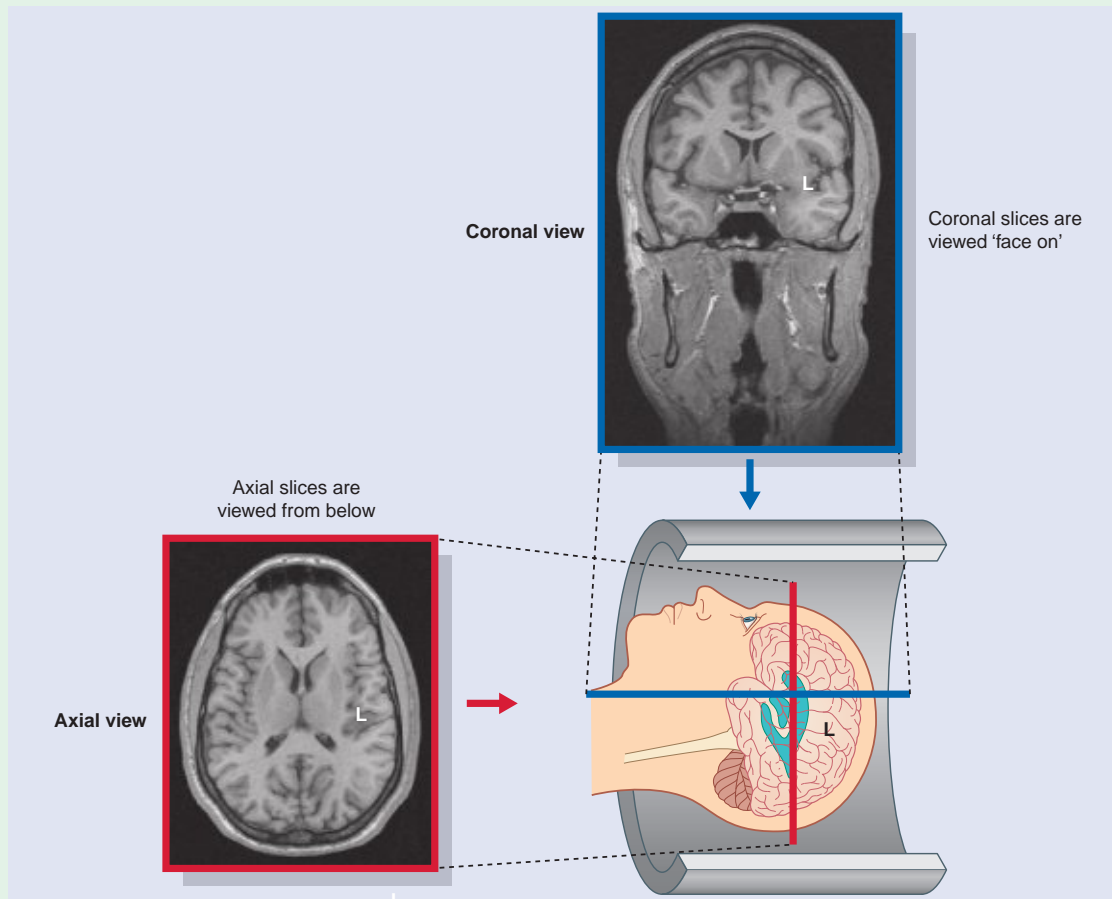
Standard orientation of magnetic resonance images. Coronal sections are viewed from in front. Axial sections are viewed from below.
